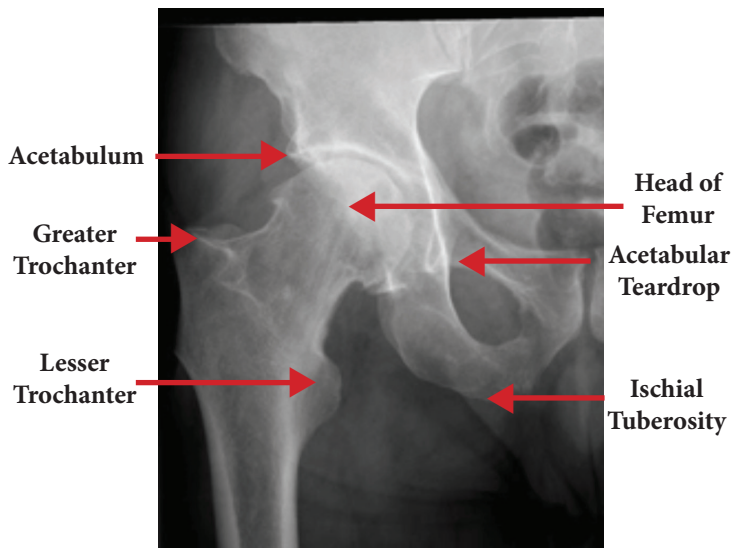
Radiographic anatomy of the hip joint
